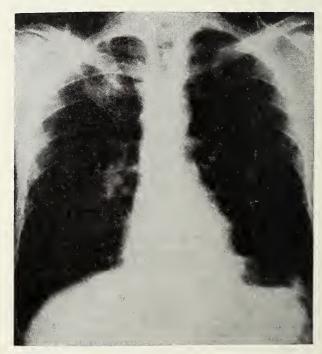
Adenocarcinoma of right upper lobe, chest x-ray PA view showing an opacity in the right upper lung region.
